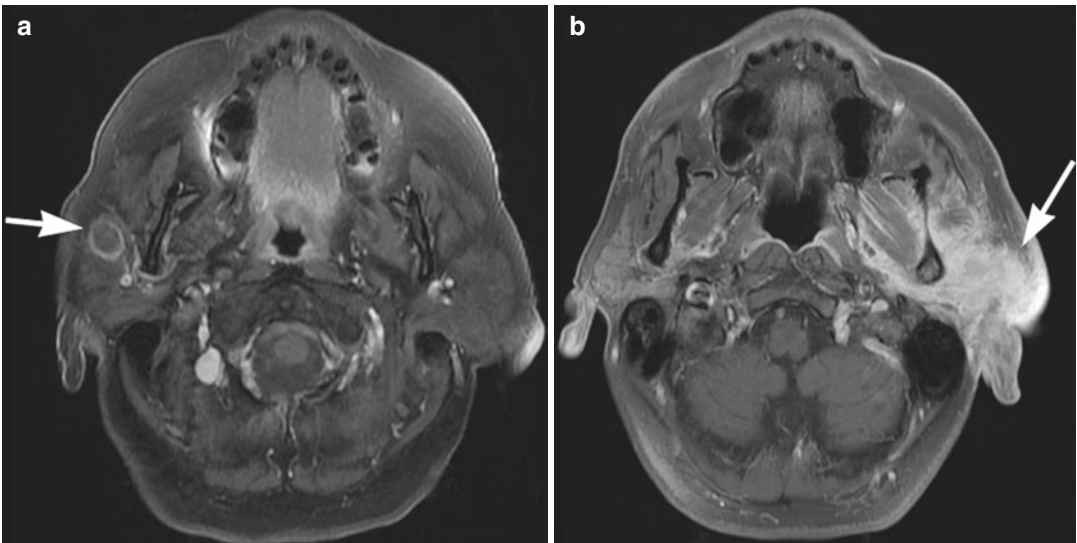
T1-weighted MR images show right intraparotid lesion (a) of low intensity and surrounding contrast enhancement (*arrow*) in a patient with metastatic squamous cell carcinoma. A left parotid adenocarcinoma
